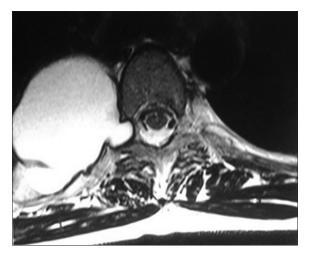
Axial T2-weighted magnetic resonance image showing a dumbbell-shaped extradural hyperintense lesion without a solid component
